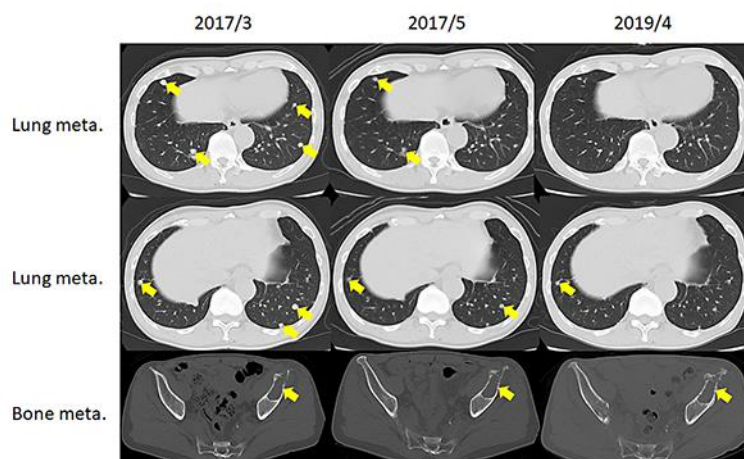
CT before initial pazopanib treatment (2017/3) as well as 2 months (2017/5) and 2 years (2019/4) after initial pazopanib treatment.
